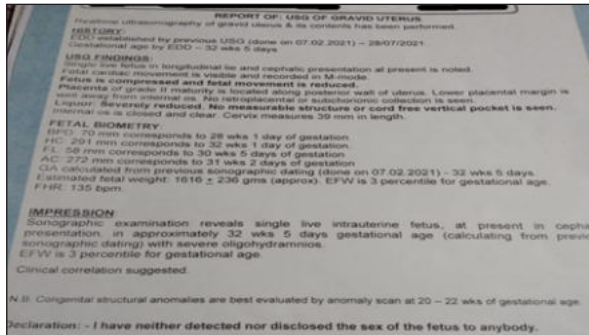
Ultrasongraphy Report Of Third Trimester
